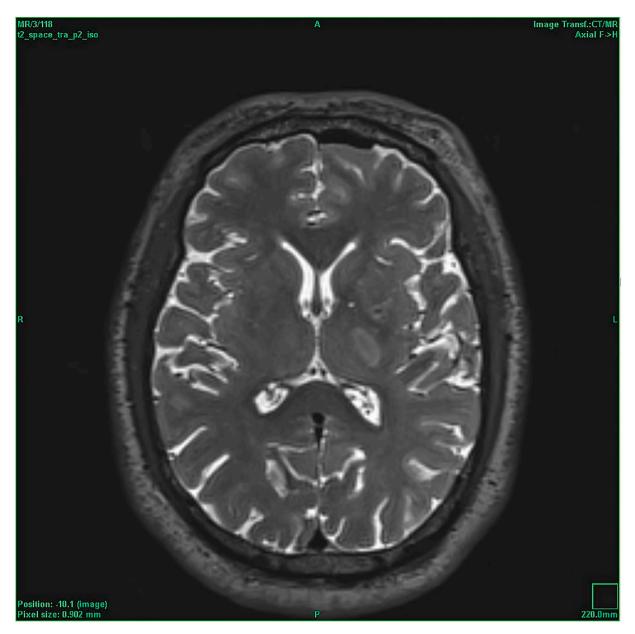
Post-operative MRI showing a lesion in the left GPi and a small infarction in internal capsule.
